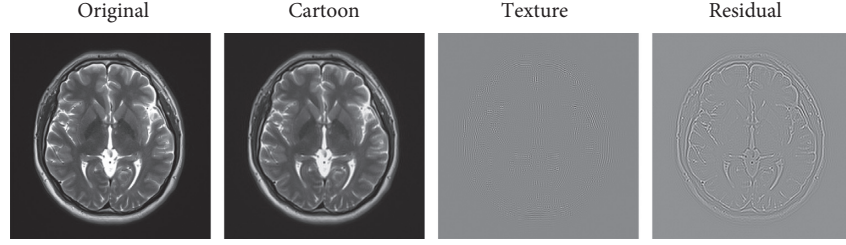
An original MRI and its decomposition based on MCA.
